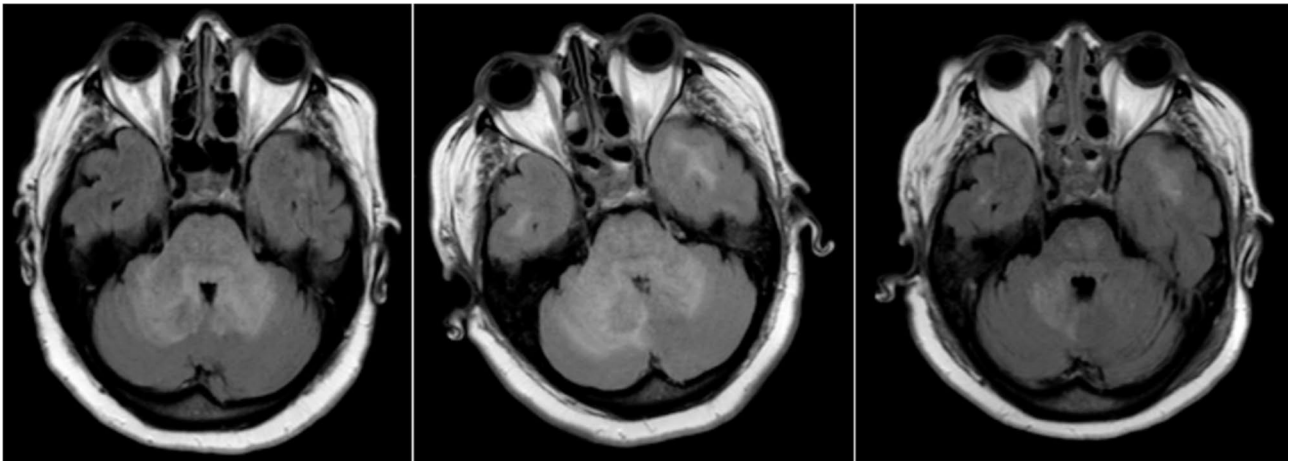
Consequent MRI scans 3, 10 and 17 days after onset
